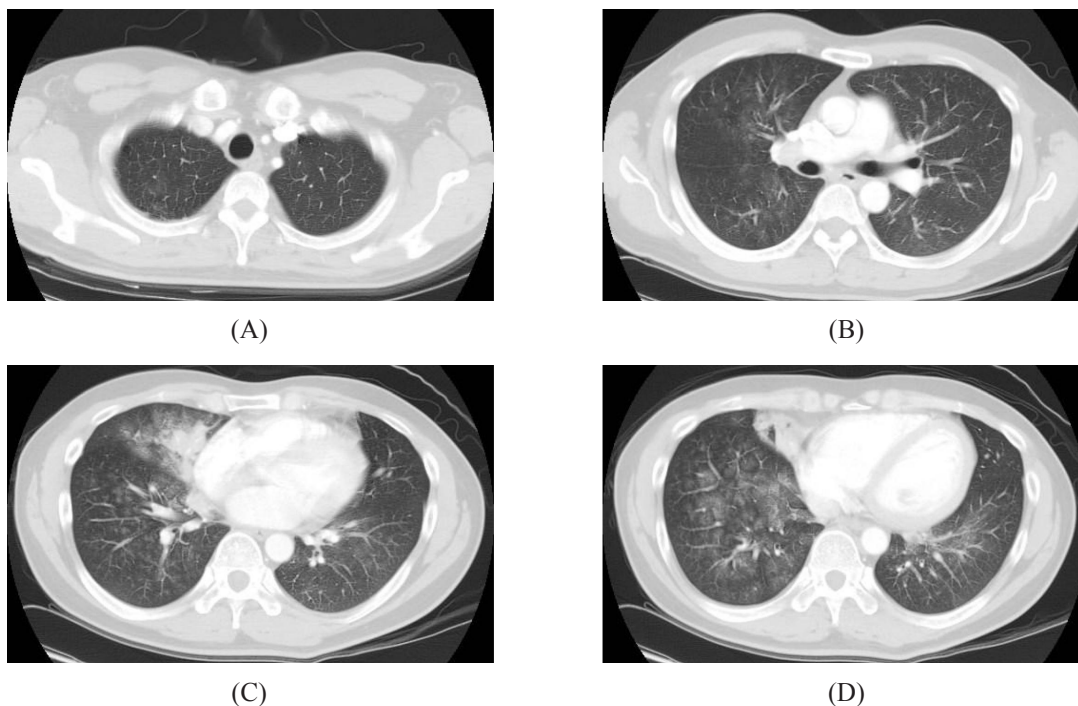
Chest CT showed patchy consolidation at the RML and bilateral diffuse centrilobular ground glass opacity, more prominent at the dependent part and lower lung.
